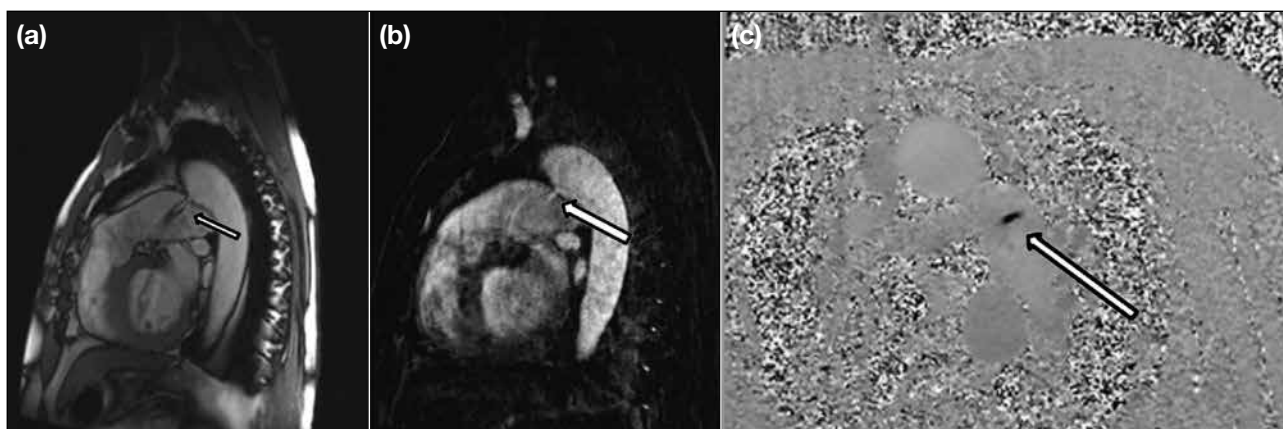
A 61-year-old man presented with wheezing and was suspected to have an aortic valvular disease. (a) Sagittal true fast imaging with steady-state free precession localiser magnetic resonance imaging (MRI) showing a 3-mm patent ductus arteriosus jet flow (arrow). A dilated pulmonary artery and ascending aorta can also be seen. (b) Sagittal post-contrast dynamic MRI with flow across patent ductus arteriosus (arrow). (c) Axial phase-contrast image marking the flow across the patent ductus arteriosus (arrow).
